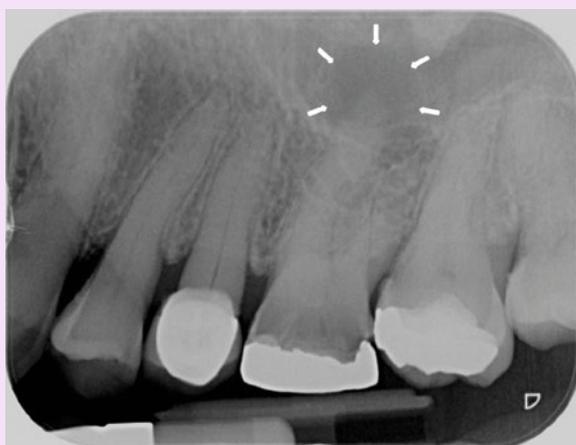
Intra-oral periapical radiograph demonstrating periapical pathosis associated with the palatal root of 26 (white arrows). When compared to air within the oral cavity, this has a radiopaque appearance. It is relatively isodense to the contents of the maxillary sinus, suggesting mucosal thickening of the adjacent maxillary sinus lining
